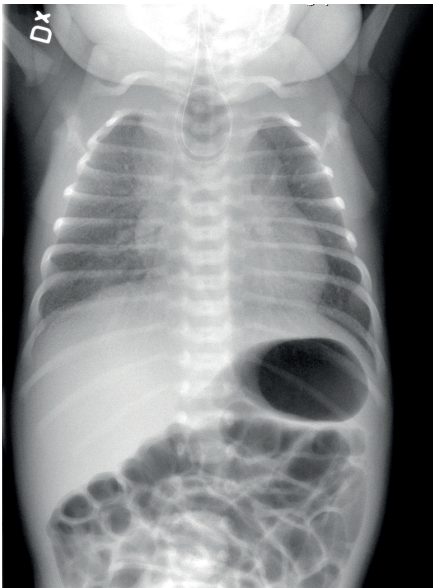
Plain x-ray of a child born with esophageal atresia
